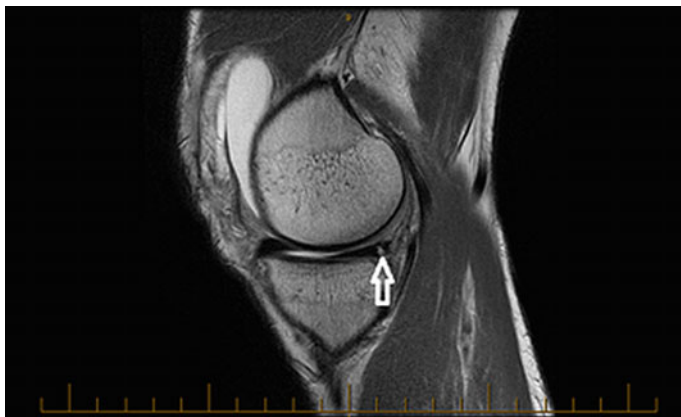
MRI view of a medial meniscus tear
